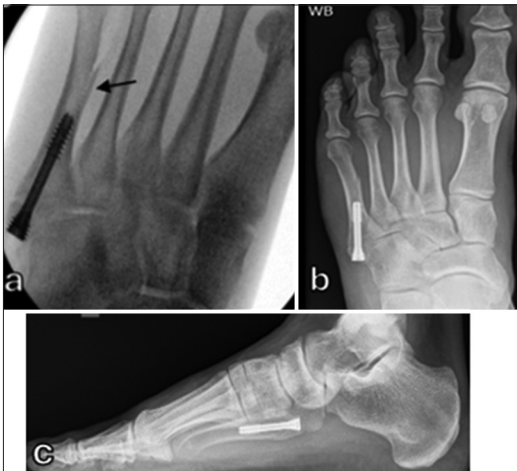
(a) Intraoperative radiograph showing iatrogenic fracture (black arrow) in the fifth metatarsal shaft following fixation with intramedullary screw. (b) Anteroposterior and (c) lateral radiographs showing both fractures united 3 months after surgery.
